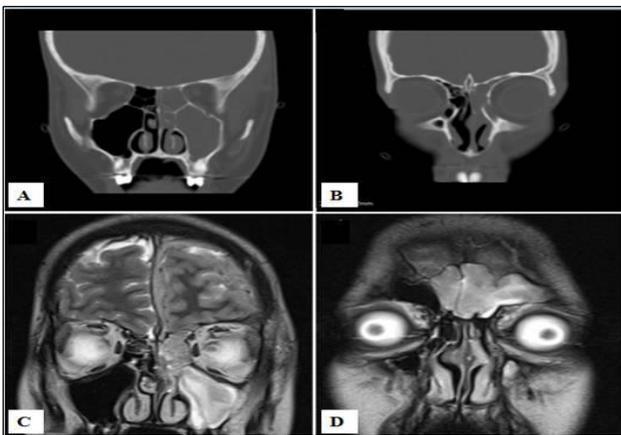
Coronal sections of paranasal Ct (a,b) and cranial MRI (c,d) show inflammatory and infective views conformable with frontal and maxillary sinusitis in the left paranasal sinuses without bone destruction.
